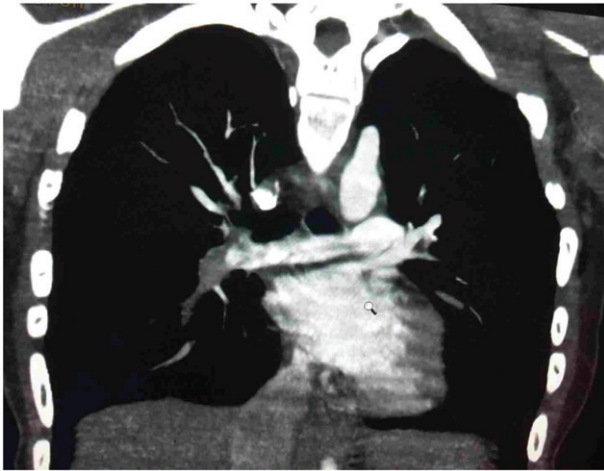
Coronal angio CT image showing pulmonary embolism.
